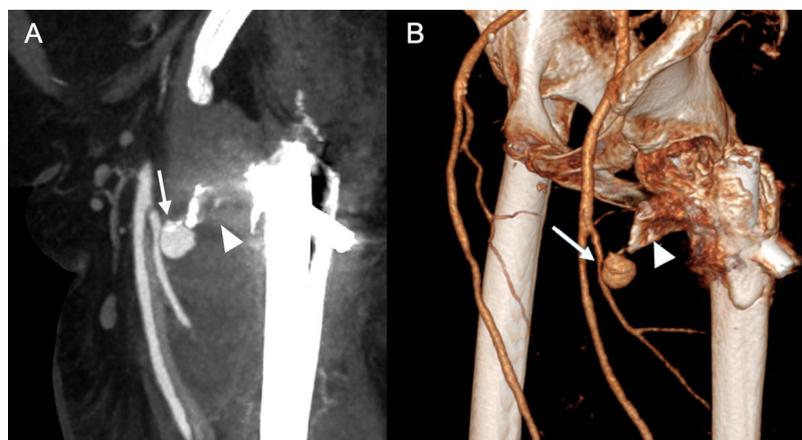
85-year-old woman who underwent surgery one month ago for fracture of the right hip. She was seen for the second time in Accident and Emergency for severe pain accompanied by induration, oedema and increased temperature in the region of the surgical wound. Sagittal maximum intensity projection (A) and 3D (B) CT angiography reconstructions of the left lower limb in arterial phase show a vascular formation arising from a perforating branch of the left deep femoral artery consistent with pseudoaneurysm. It remains in intimate contact with a displaced bone fragment that appears to be attached to the femur (arrowhead).
